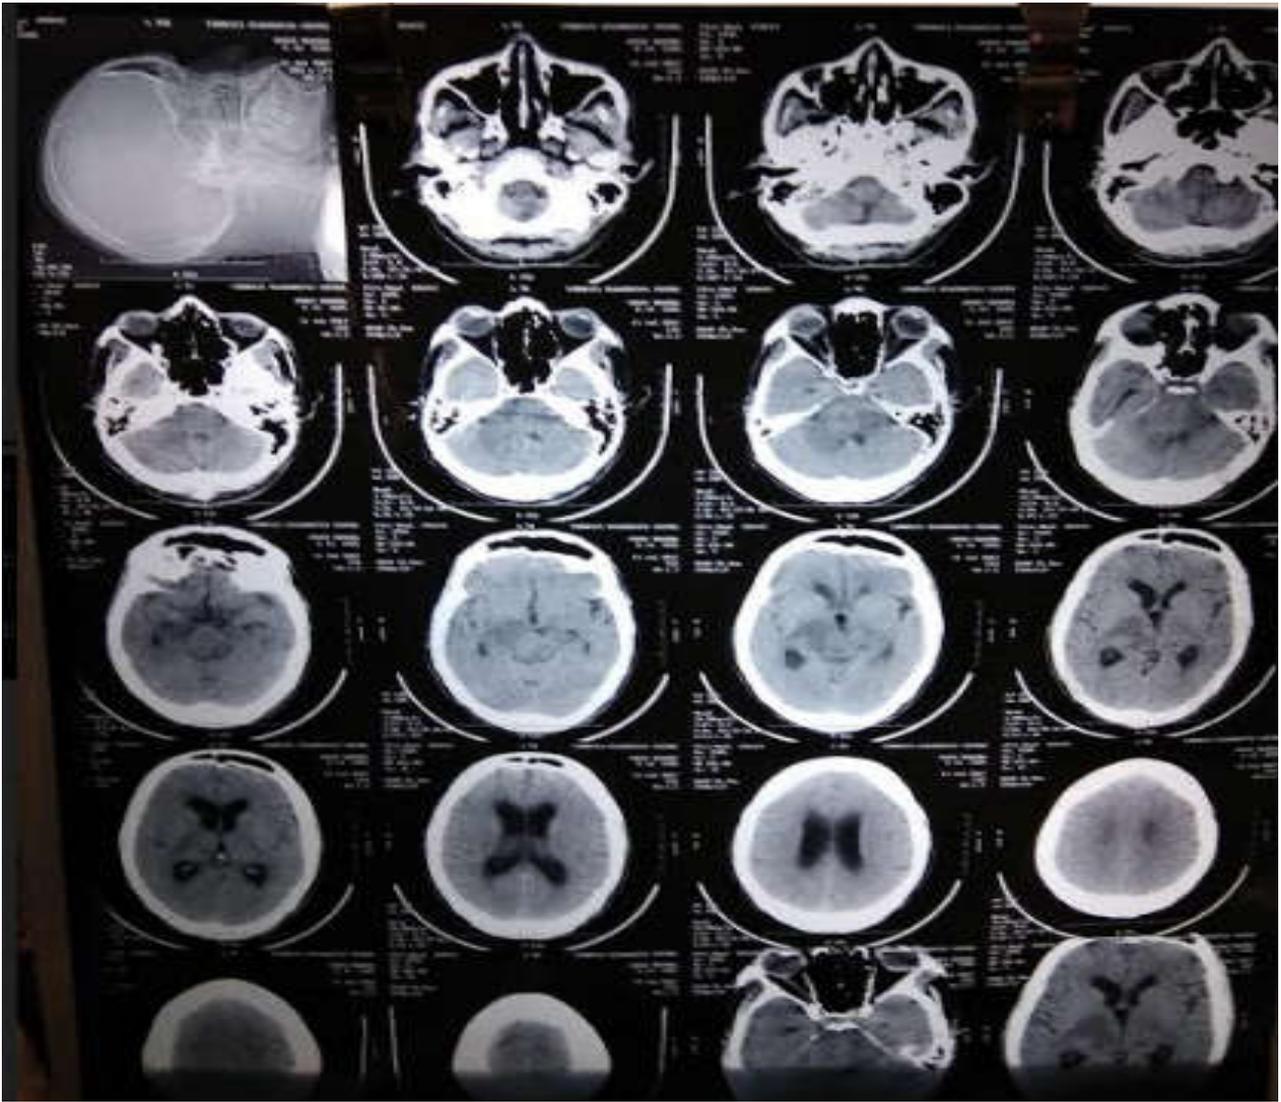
CT scan of brain a heterodense area in brainstem with mass effect over 4th ventricle with dilatation of supratentorial system. Right thalamic region shows hypodense area? Infarction
